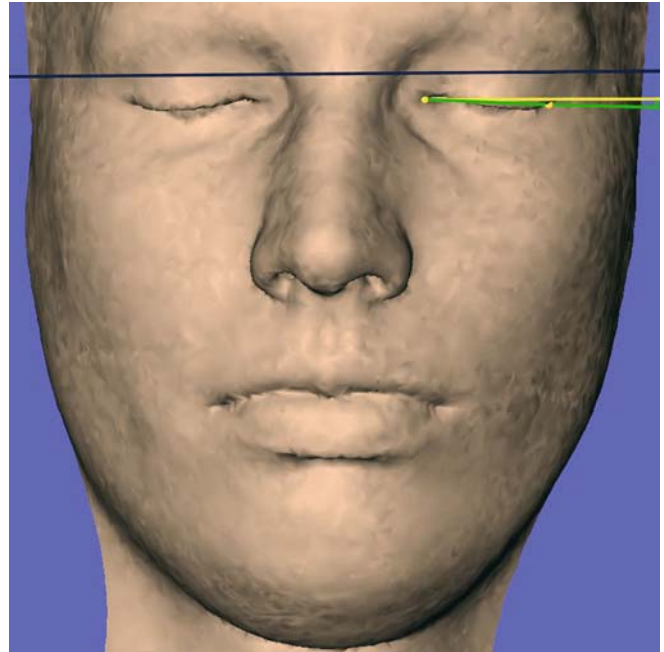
The inclination of the left eye-fissure from the horizontal plane, ex_l-en_l / x -plane, is a projected angular soft tissue measurement on the vertical (y) 3-D cephalometric reference plane (3-D CT, soft tissues, patient K.C.)
